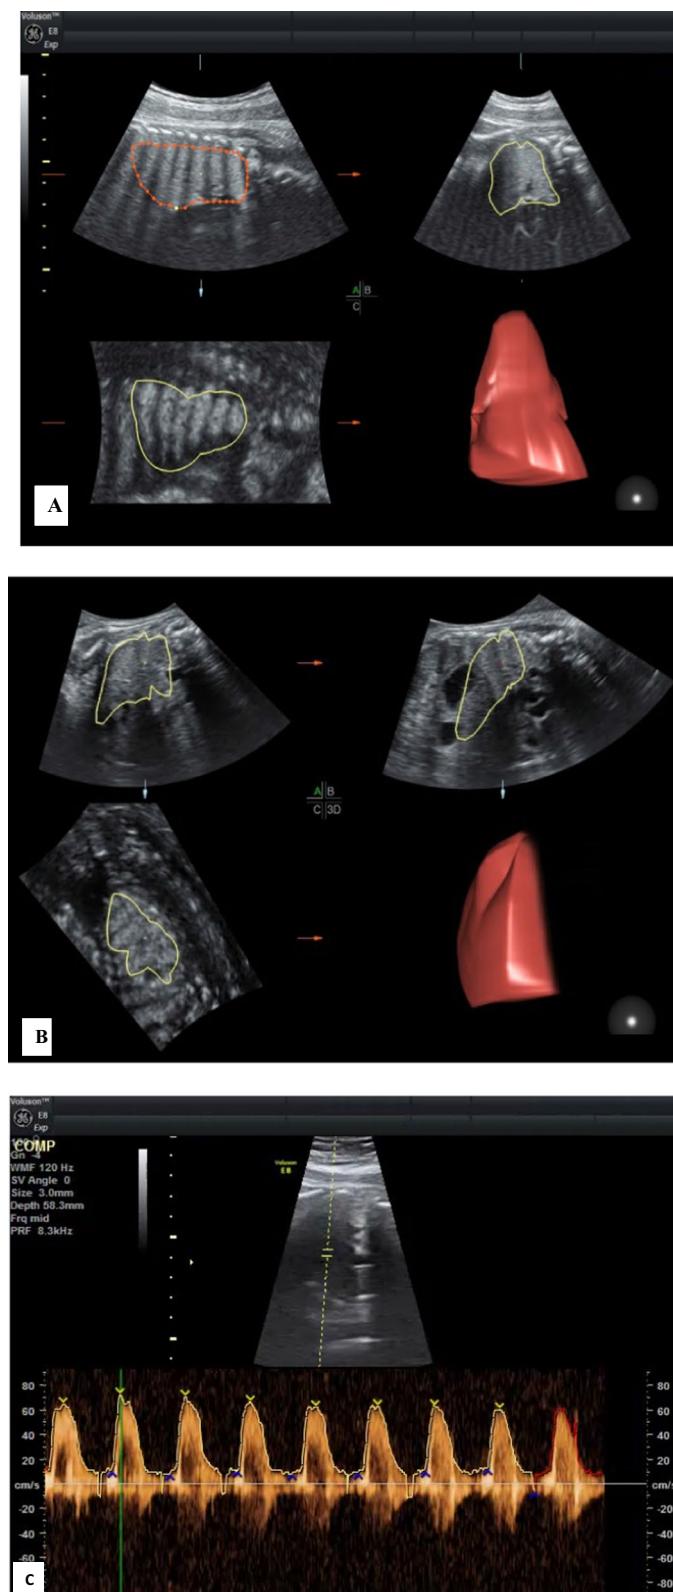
A–C Lung volume of pregnant patient 23 years old, GA=(34 wks + 0 ds) calculated by 3D US using VOCAL technique showing: the volume of right lung (A) and left lung (B) 31 cm³ and 29 cm³, respectively. C The pulmonary artery resistance index (RI) of the same patient measured by pulsed Doppler RI=0.74. (Neonate with mild RD admitted to ICU for 2 days)
